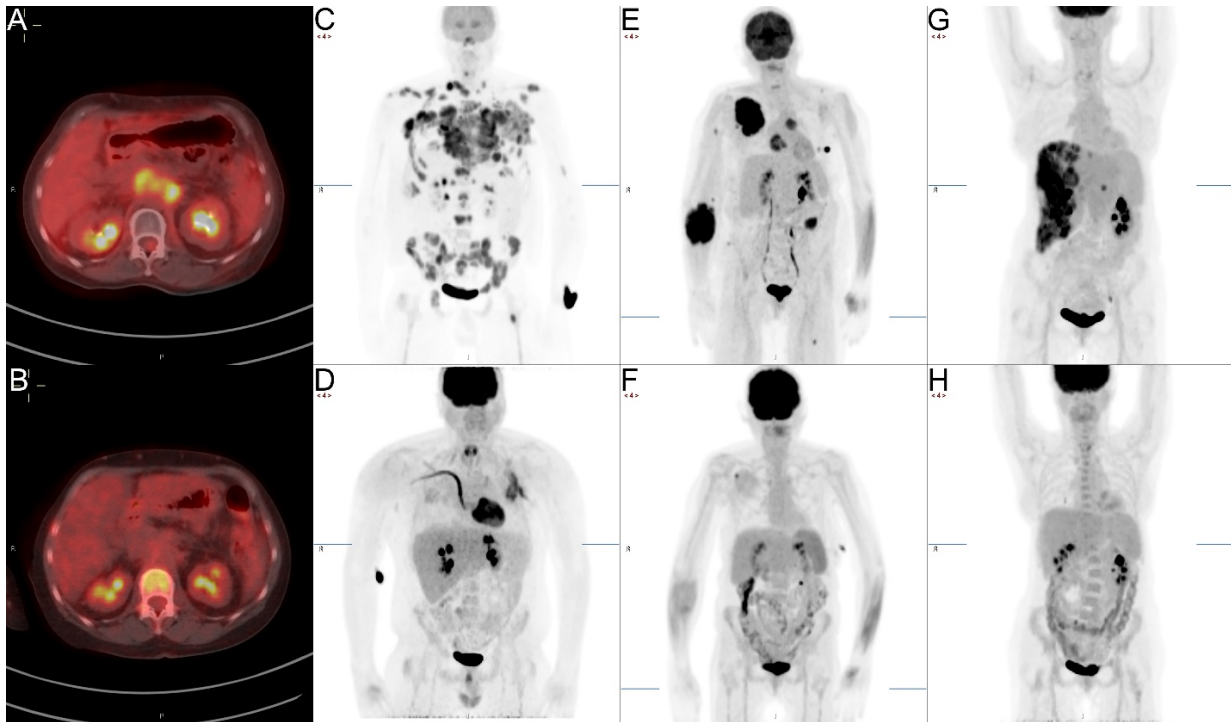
In some patients who achieved a CR, an FDG-negative residual mass could still be observed, but this mass remained stable or regressed over time. Radiologic tumor regression was usually observed after the first cycle.
